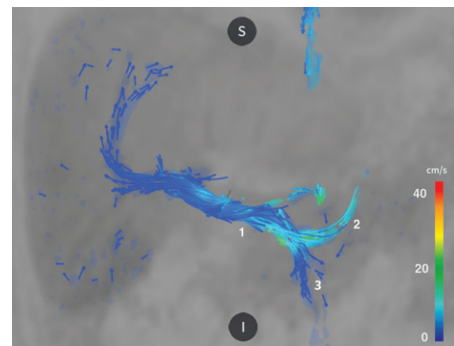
Suspected congestive hepatopathy in a 30-year-old woman years after Fontan operation. Image from 4D flow MRI shows normal and continuous flow in the portal vein (1), with laminar helical flow seen after the confluence of the splenic vein (2) and superior mesenteric vein (3). Velocity vectors demonstrate normal continuous hepatopetal flow.
